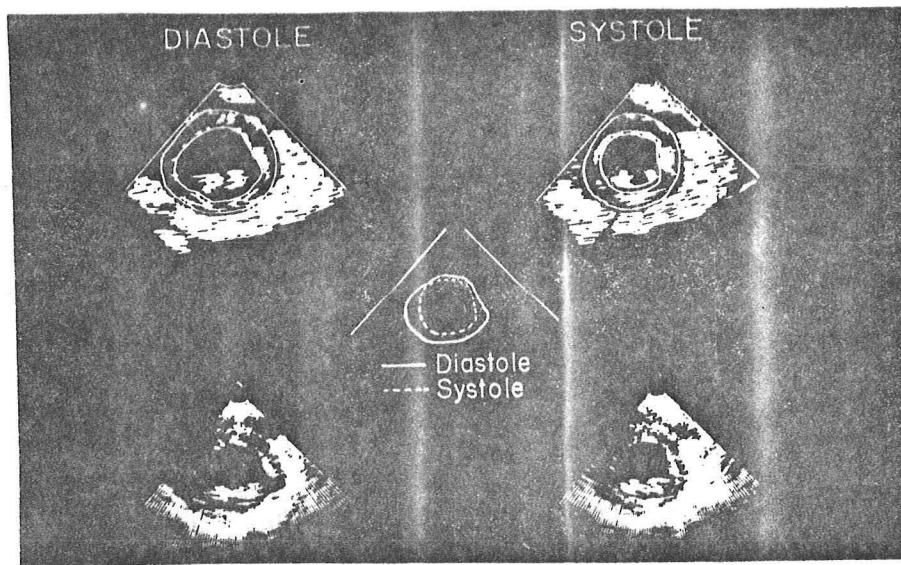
Two-dimensional echocardiogram in an acute anterolateral myocardial infarction (63).
